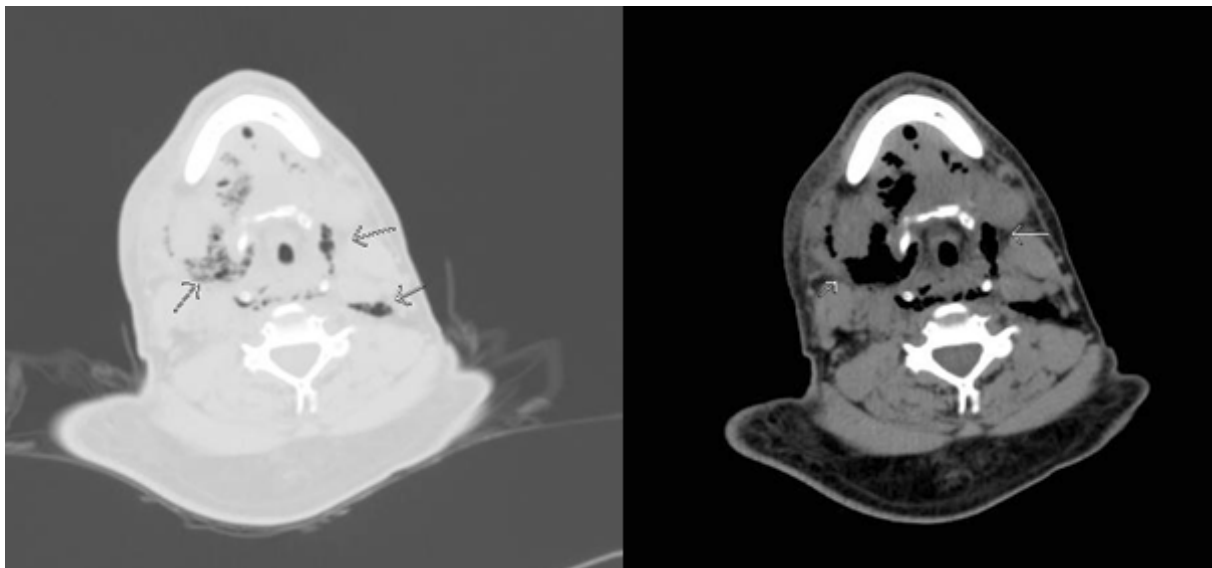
CT of the neck and cervical region.
